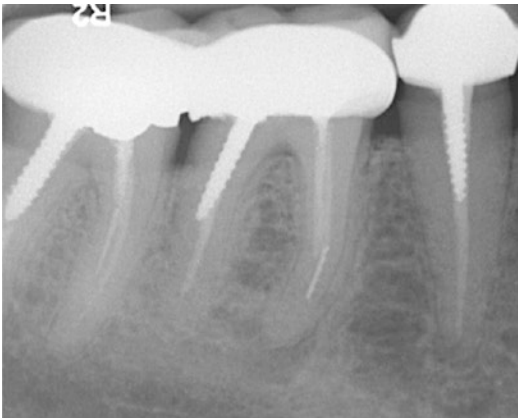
Surgical treatment of a root perforation. A 35-year-old male patient presented with pain in the area of a mandibular left molar. (a) A periapical radiograph revealed an iatrogenic root perforation with associated periodontal damage in the mesial aspect of the mesial root
